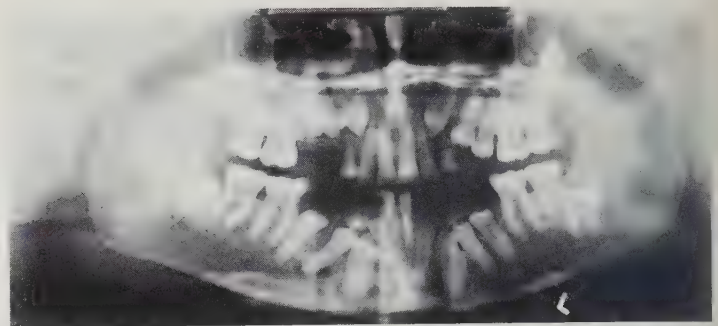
Panorex radiograph d'inclusion dentaire.
